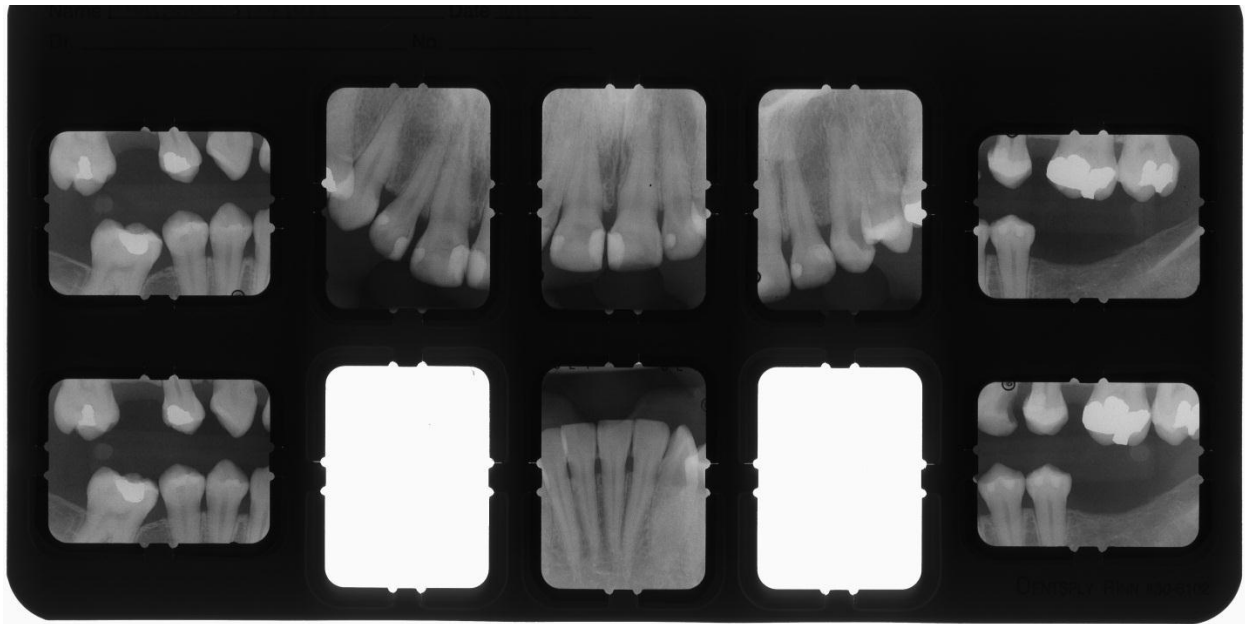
Radiograph with evidence of bone loss.
